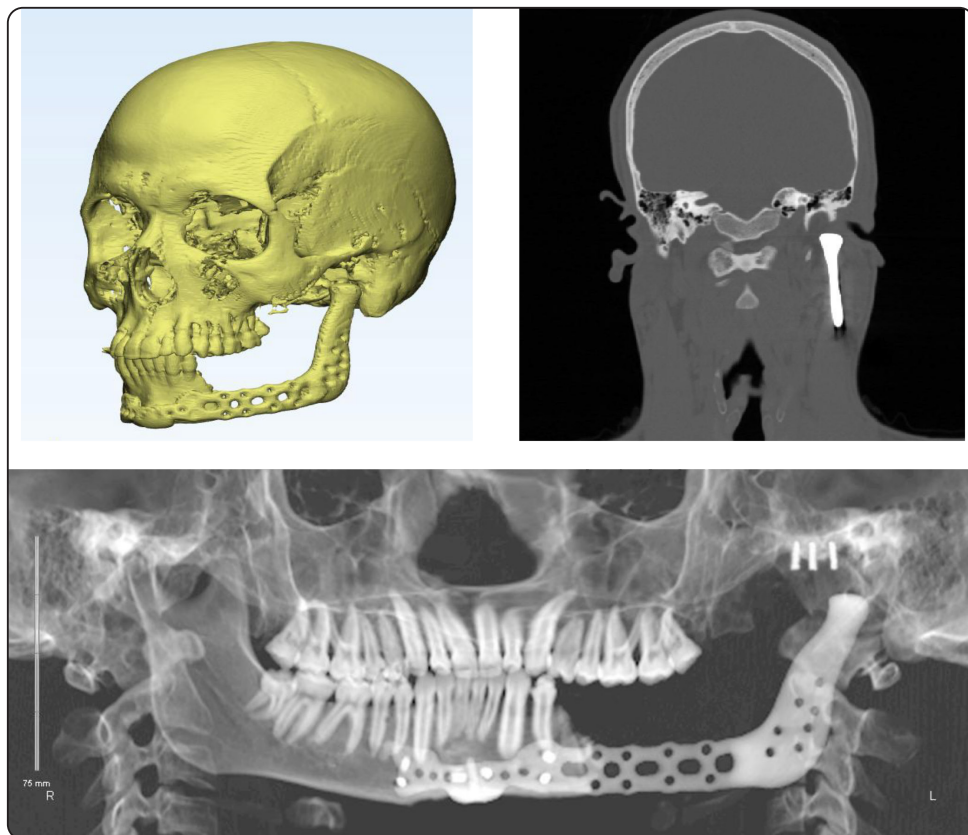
Showing 3D reconstruction, coronal view and panoramic CT view after 1 follow-up.
